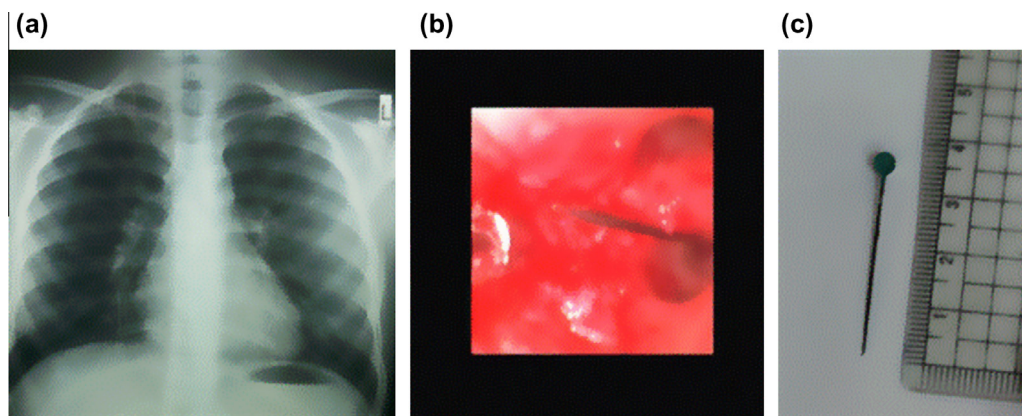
(a) Chest X-ray shows a pin in the right lower lobe. (b) Bronchoscopic image shows the pin with its free tip upward. (c) Picture of the pin after removal by flexible bronchoscopy.
